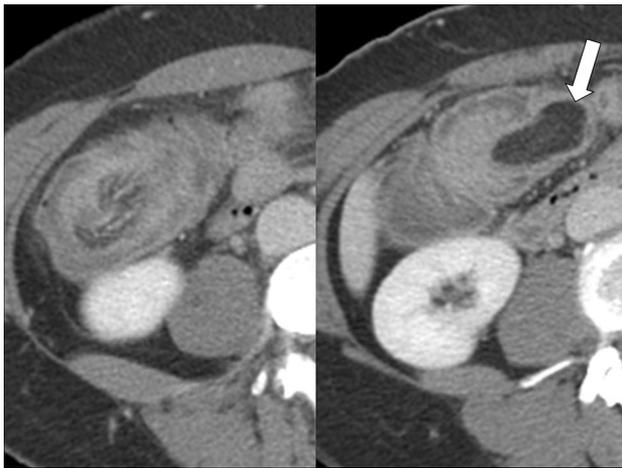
A 41-year-old woman with intussusception. Enhanced CT shows a bowel-in-bowel appearance in the right abdomen (left). An ovoid, slightly lobulated, lipid-attenuated mass is seen within the bowel as a leading cause (arrow, right). This mass was a lipoma in the ileum, causing ileocolic intussusception
